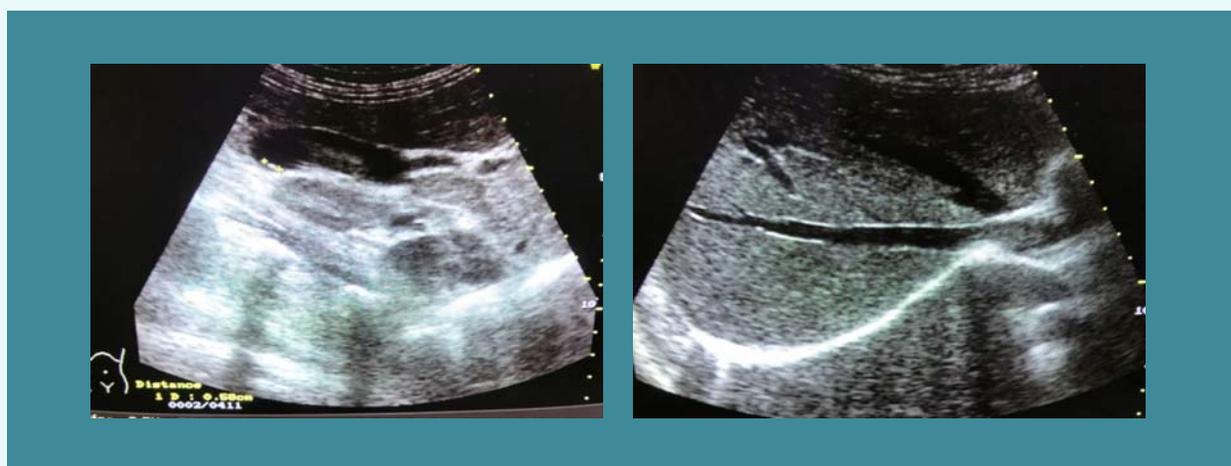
Ultrasound of the liver and gallbladder that showed normal structure of the liver with a possible polyp on the gallbladder wall
